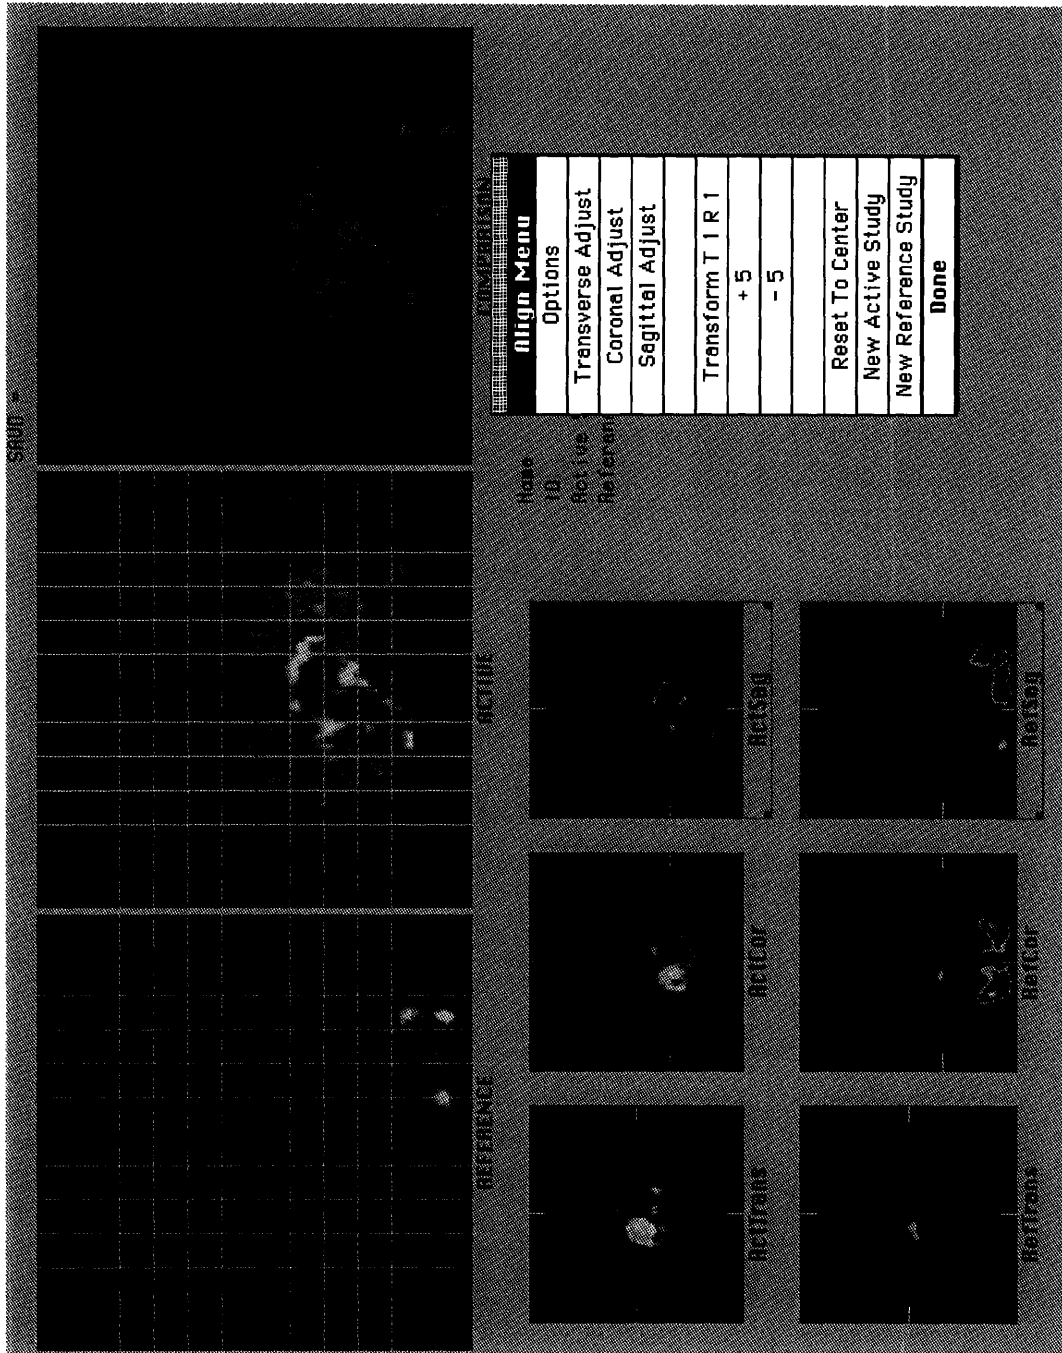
Thallium-201 brain SPECT and MRI registration.
